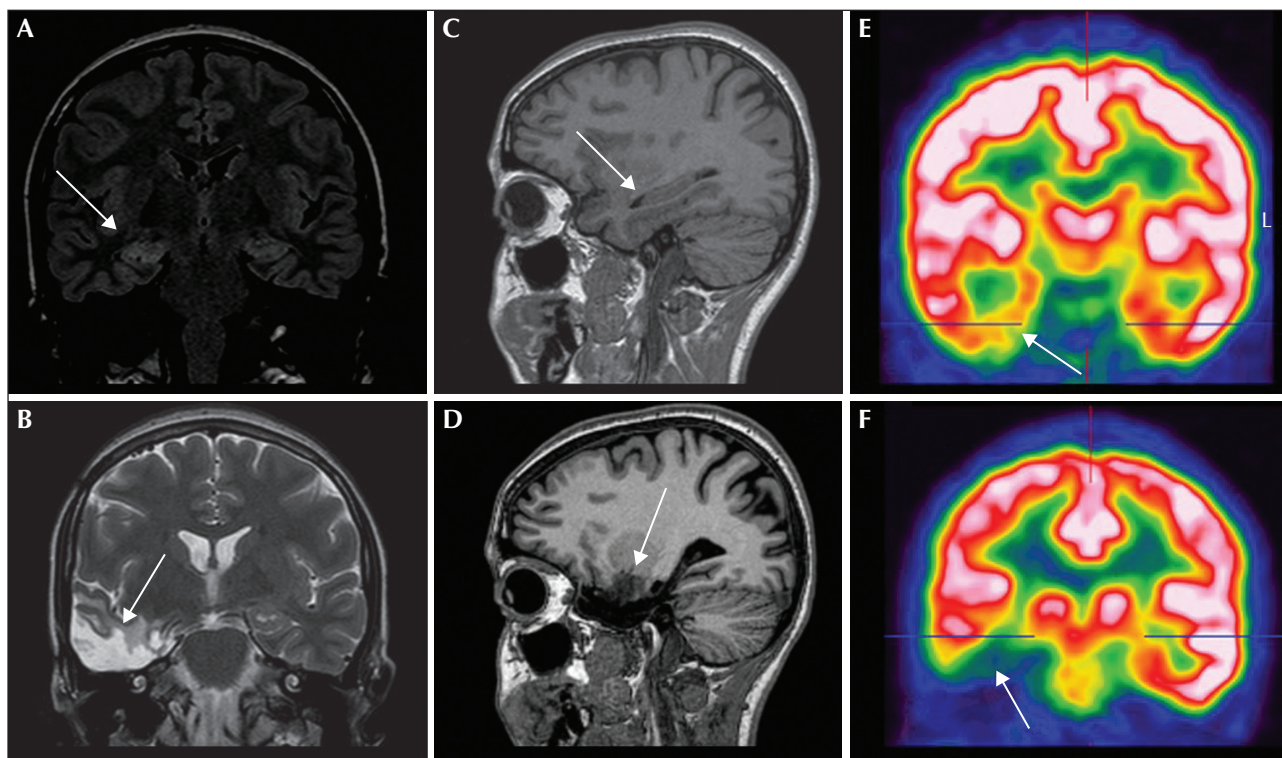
Coronal and sagittal planes of brain MRI and interictal ^{18}F -FDG PET showing preoperative right hippocampal sclerosis (A, C); preoperative hypometabolic zone in the right mesiotemporal region (E); postoperative sequel after standard right temporal lobectomy with amygdalohippocampectomy (B, D); and postoperative amebolism zone in the right mesiotemporal region only (F) (the arrows in each panel refer to each respective finding).
